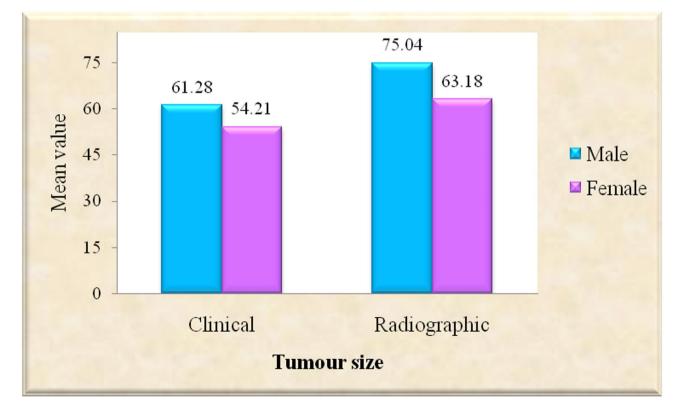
Comparison of tumour size between clinical and Radiographic (Mean ± SD in mm)
